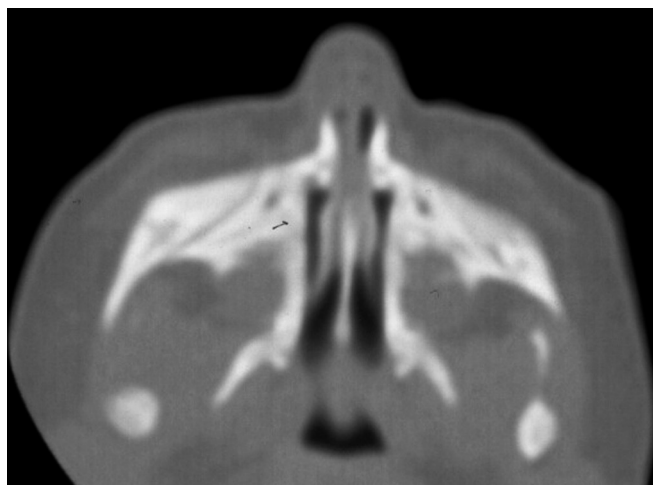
Axial CT scan demonstrating pyriform aperture stenosis.
